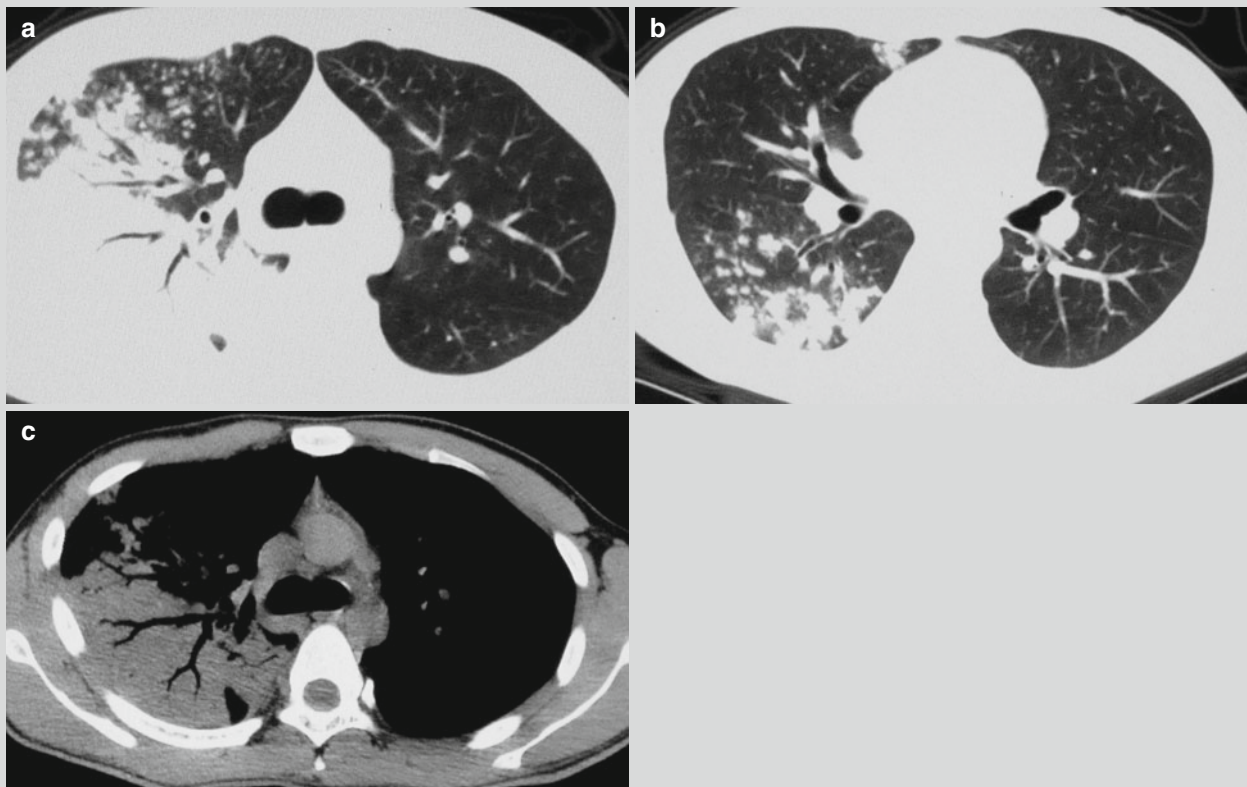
Tubercular lobar pneumonia. (a–c) CT scanning demonstrates a large flake of consolidation at the right upper lung lobe with inner air bronchus sign. The margin of lesions is demonstrated
